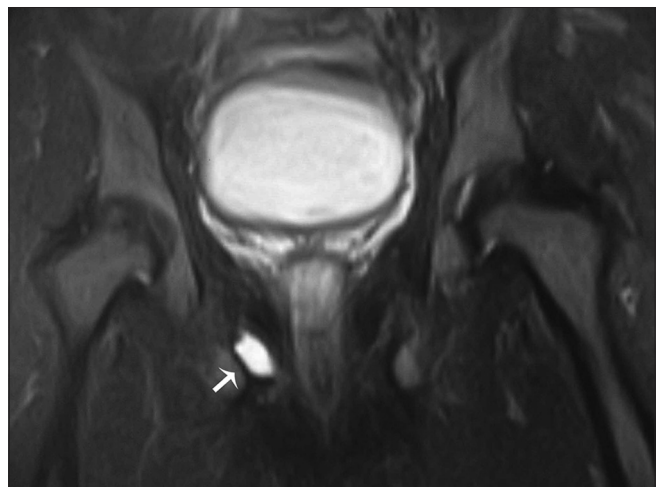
MRI showing small fluid collection adjacent to right ischial tuberosity suggesting an infective etiology
